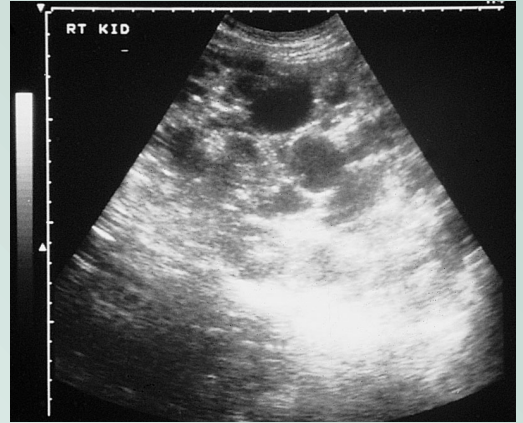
B Ultrasound of a polycystic kidney. Cysts of different sizes are scattered throughout the kidney substance and can be seen as round black shapes.
